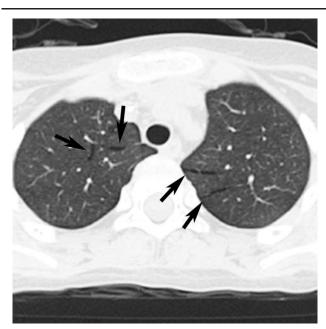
PIE (interlobular septal type) on CT in an 8-year-old female patient with aplastic anemia, with a history of allo-HSCT, and with a conservative treatment duration of 4 days. PIE-linear air around interlobular septal (black arrow). CT=computed tomography, PIE=pulmonary interstitial emphysema.
